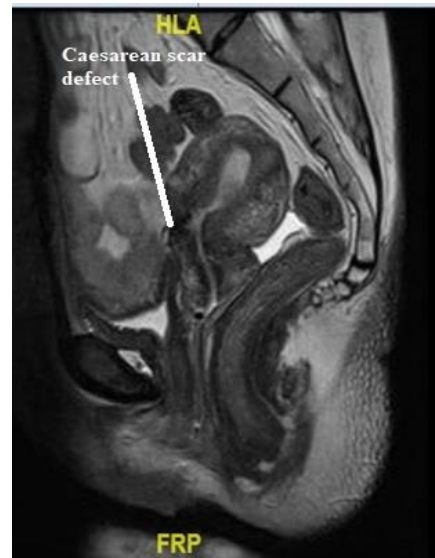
MRI pelvis (contrast)- retroverted uterus with a focal semicircular disruption of the ventral myometrium at the LSCS scar site extending through the serosa with tethering of the endometrium towards the scar site.
